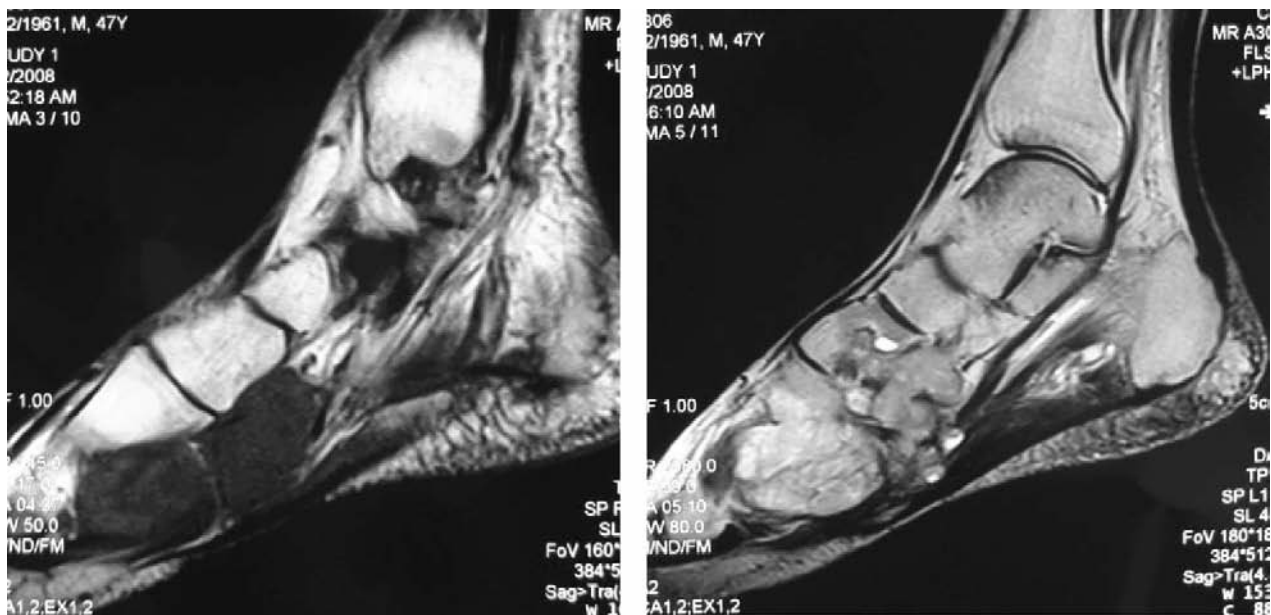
T1-weighted MRI slice shows a low signal intensity mass; T2-weighted MRI slice shows the lobulated mass with high signal intensity and obscure boundary.
